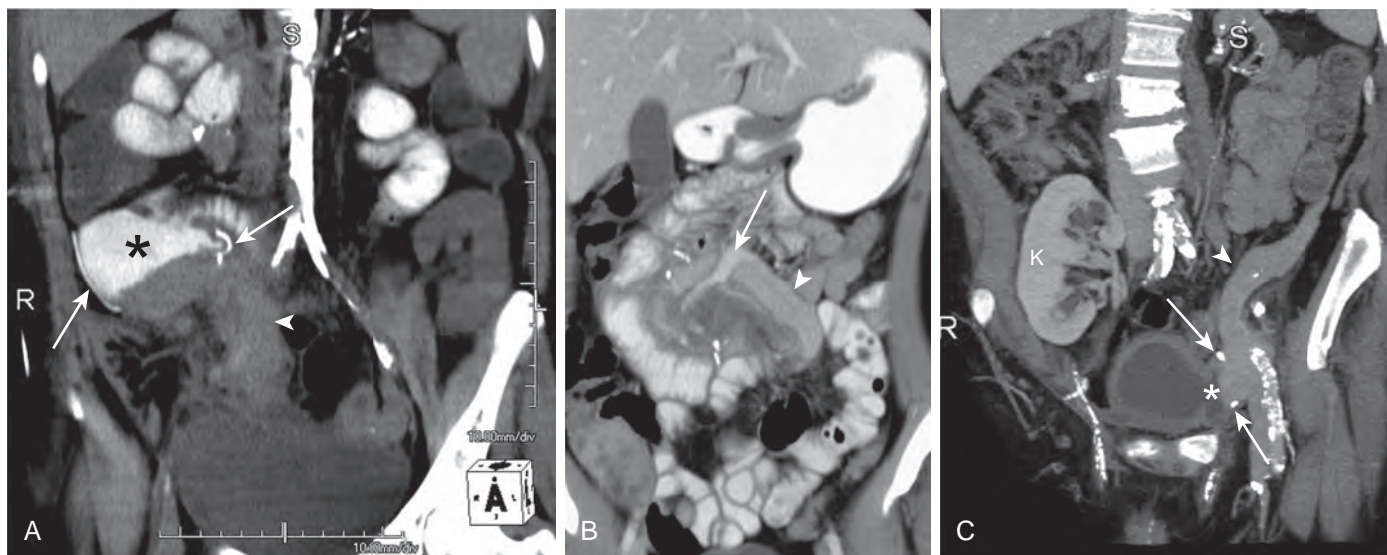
Normal CT appearance of pancreas transplant in different patients. A. Coronal maximum intensity projection image from unenhanced CT shows surgical staple lines (arrows) along the duodenal stump (asterisk), aiding localization of the pancreas transplant (arrowhead). B. Coronal multiplanar reconstruction image shows a patent graft vein (arrow) with normal parenchymal enhancement of the pancreatic body and tail (arrowhead). C. Coronal anterior oblique 8-mm maximum intensity projection image from an enhanced CT study of a bladder-drained left lower quadrant pancreas allograft transplanted after a renal transplant (K) shows surgical staple lines (arrows) along the lateral margins of the duodenal stump, which aids in the identification of the duodenocystostomy (asterisk). The pancreas transplant (arrowhead) is readily identified with normal parenchymal enhancement. (From Vandermeer F, Manning MA, Frazier A, et al: *Imaging of whole-organ pancreas transplants*. *RadioGraphics* 32:411–435, 2012.)
